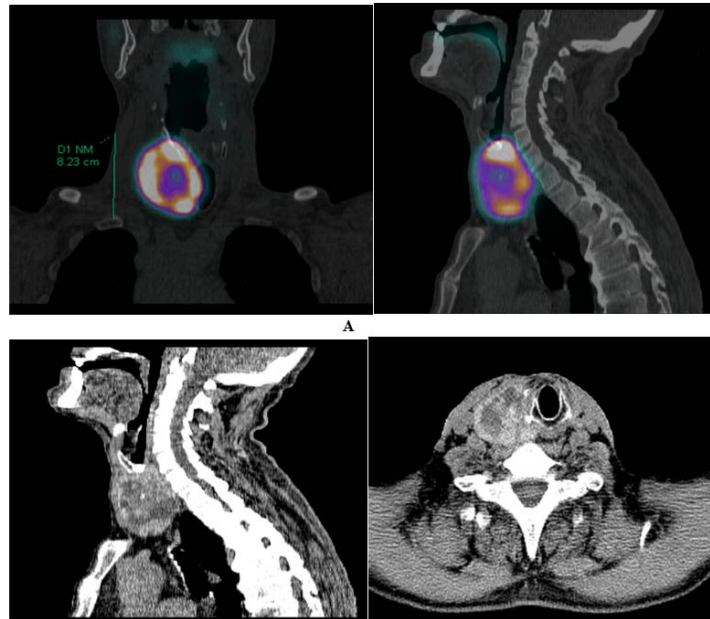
40-year-old male patient, laboratory picture of thyrotoxicosis, on the projection of the right lobe of the thyroid gland, a round-shaped formation of inhomogeneous structure was observed on the ultrasound examination, the right lobe size of the gland is significantly enlarged image shows the presence of a large hot nodule, for which, in addition, a) photon emission computed tomography was used with the patient - SPECT/CT, the projection of the right lobe of the thyroid gland shows a "hot" nodule of 8 cm in size, the mentioned nodular formation of the. b) Computed tomography exerts pressure on the esophagus, trachea and causes its deviation to the left, the spread of the nodule in the mediastinum area is not fixed.
